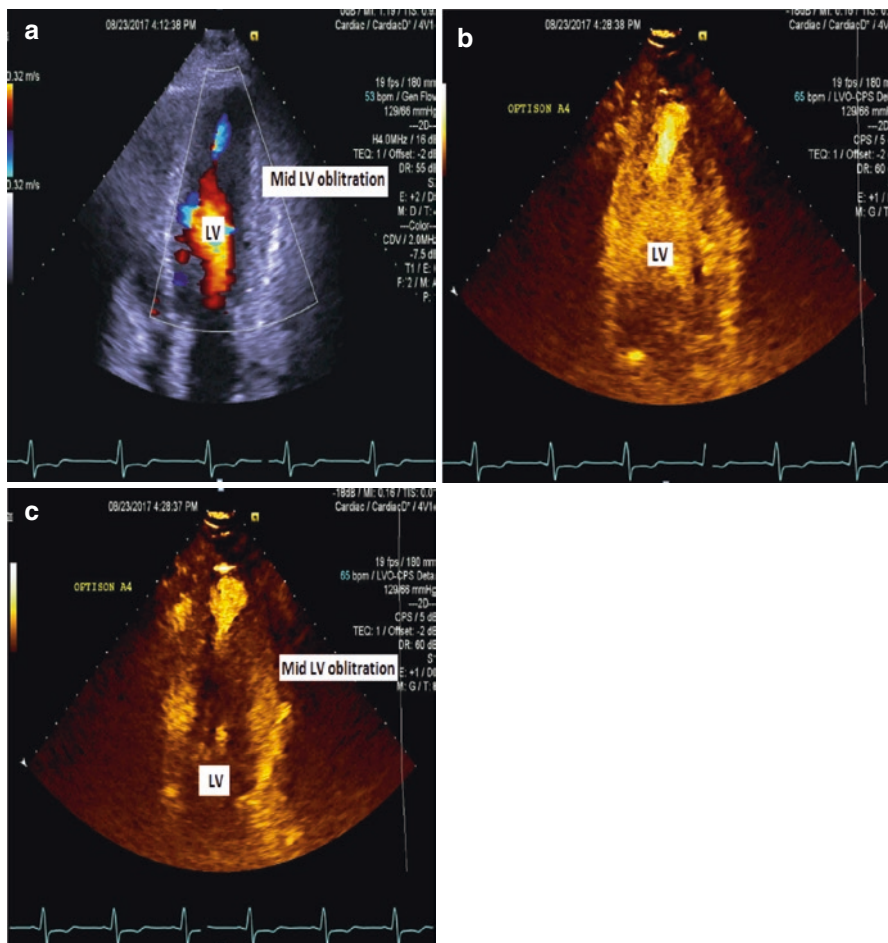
A 72-year-old woman with past medical history of hypothyroidism, hypertension, and coronary artery disease admitted for severe diarrhea and progressive shortness of breath. She had a cardiac arrest secondary to wide complex tachycardia. Bedside transthoracic echocardiography showed the following: (a) Apical four-chamber view: severe left ventricle hypertrophy with small cavity and turbulent flow in mid-ventricle. (b) Apical four-chamber view in diastole after contrast injection. (c) Apical four-chamber view in systole after contrast injection showing mid left ventricular obliteration. LV left ventricle
